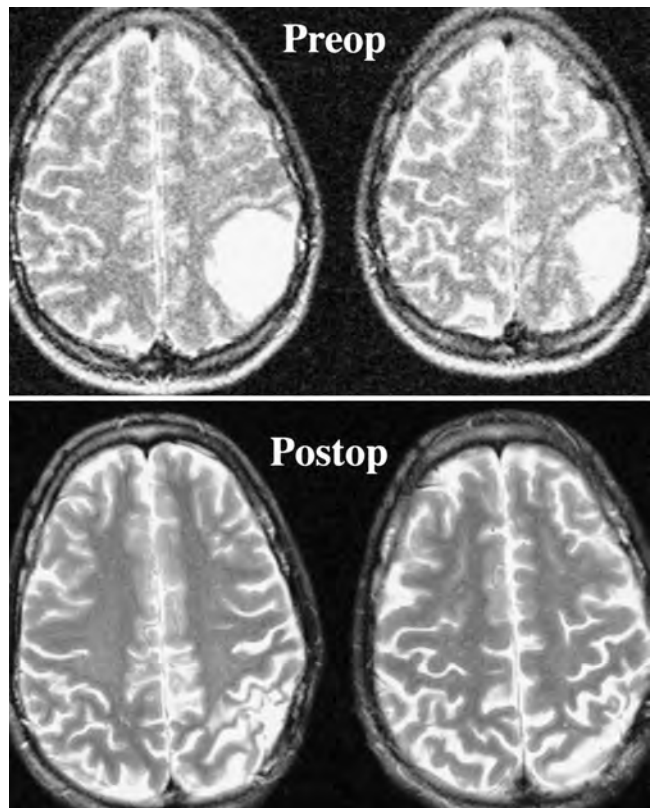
Case 2. *Upper*: Preoperative MR images revealing a 4-cm nonenhancing glial tumor in the left inferior parietal lobule, which is displacing the surrounding cortical sulci. *Lower*: Postoperative MR images obtained after gross-total resection of the lesion.
